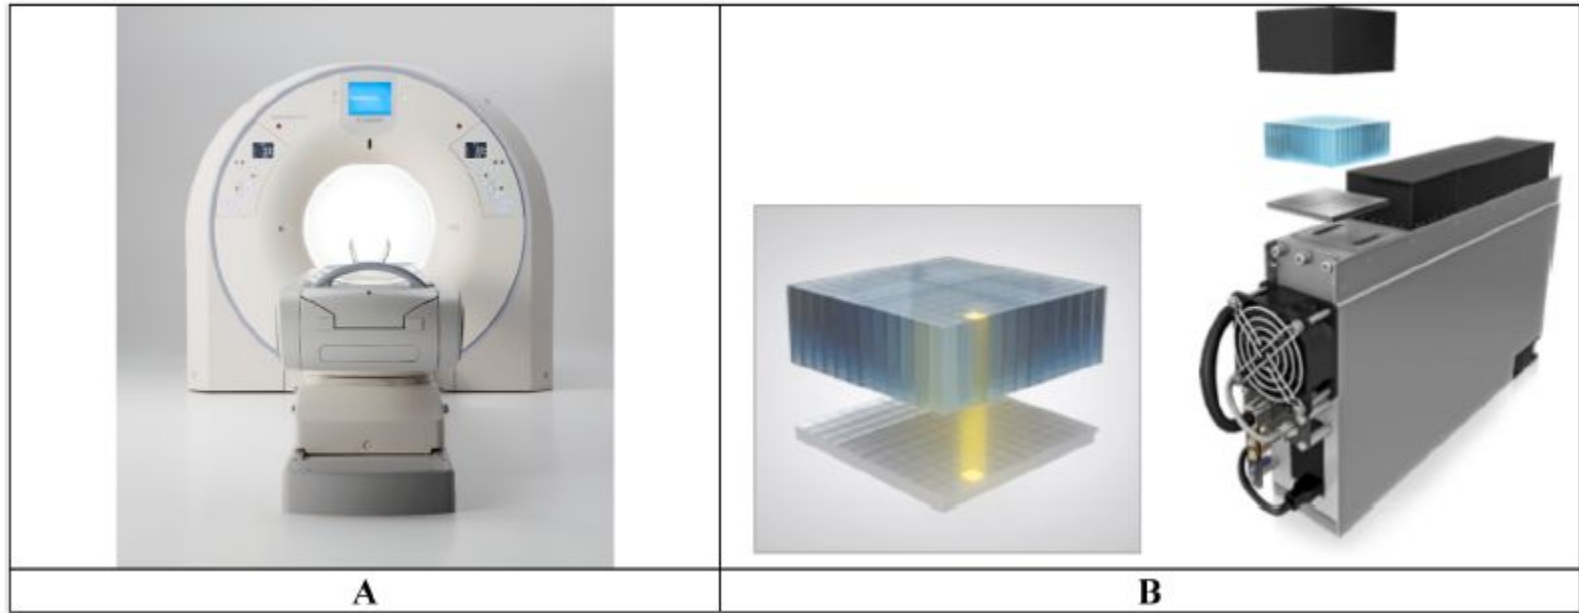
(A) Picture of the Siemens Biograph Vision PET/CT. (B) Picture of a mini-block (5×5 array of $3.2 \times 3.2 \times 20 \text{ mm}^3$ LSO pixels), a 2×2 array of mini-blocks coupled to a 2×2 array of SiPMs (each a 4×4 array of SiPM channels), a detector block composed of a 4×2 array of mini-blocks, and a detector electronic assembly (DEA) of comprising of 2×4 array of detectors and associated electronics. Pictures courtesy of Siemens Healthineers.
